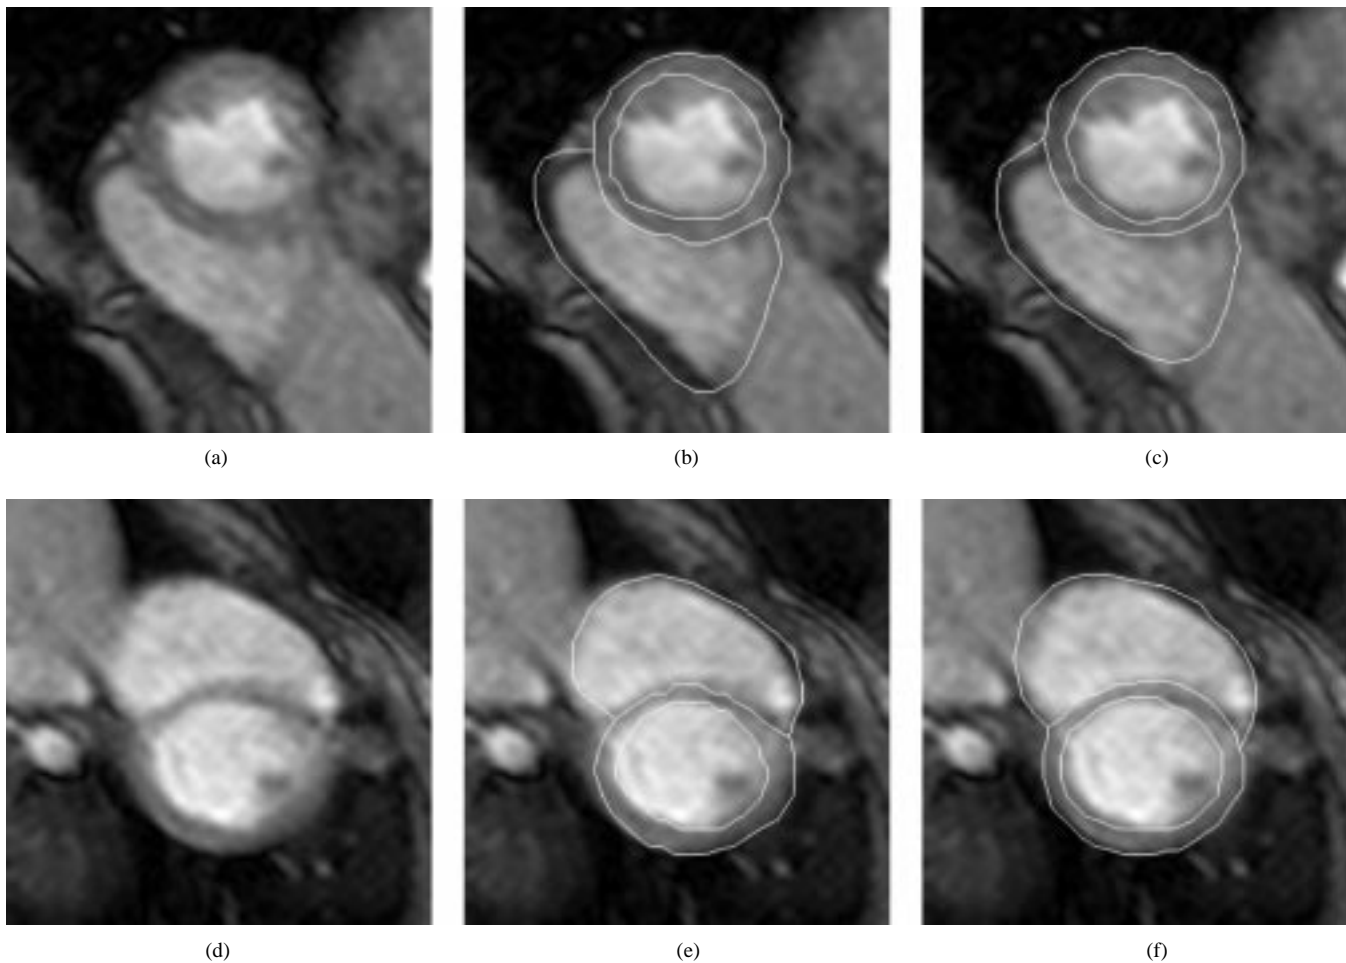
LV and RV contours obtained by our multistage hybrid ASM/AAM segmentation method in cardiac MR images. Presented examples are from the testing set. (a) and (d) Show the originals, (b) and (e) the independent standard. (c) and (f) Show the results of our multistage segmentation method. See Fig. 3 for the full-size original images that were analyzed using our fully automated approach.
